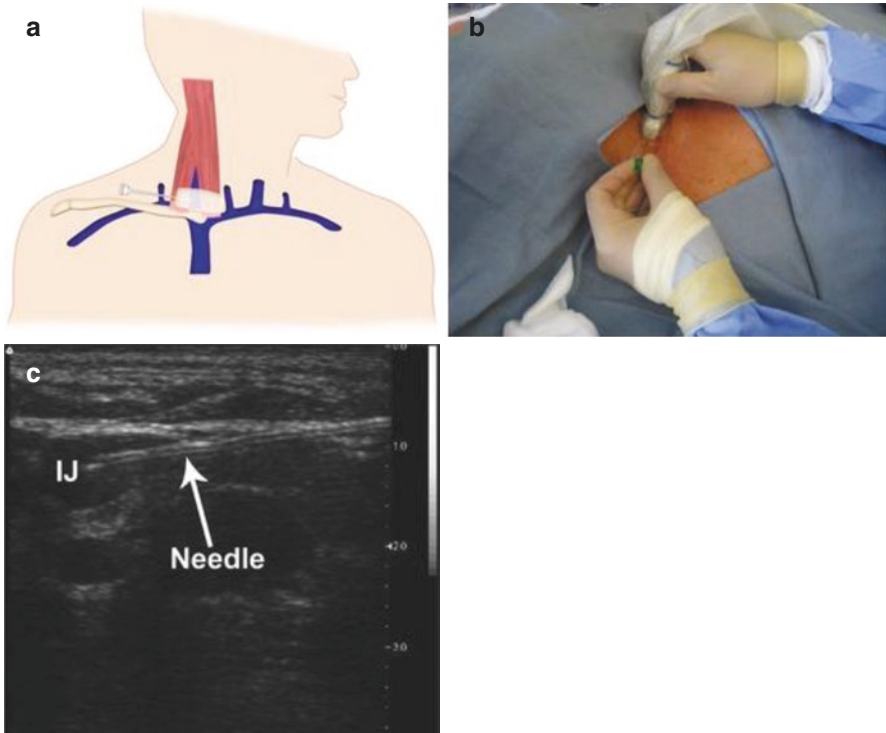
(a) Insert the needle at the midpoint on the lateral aspect of the probe under real time ultrasound imaging. (b) Advance the needle under ultrasound guidance. The needle should be moving parallel to the superior border of the ultrasound probe to stay within the ultrasound plane. (c) The needle should be visualized to enter the IJ vein on real-time ultrasound imaging
